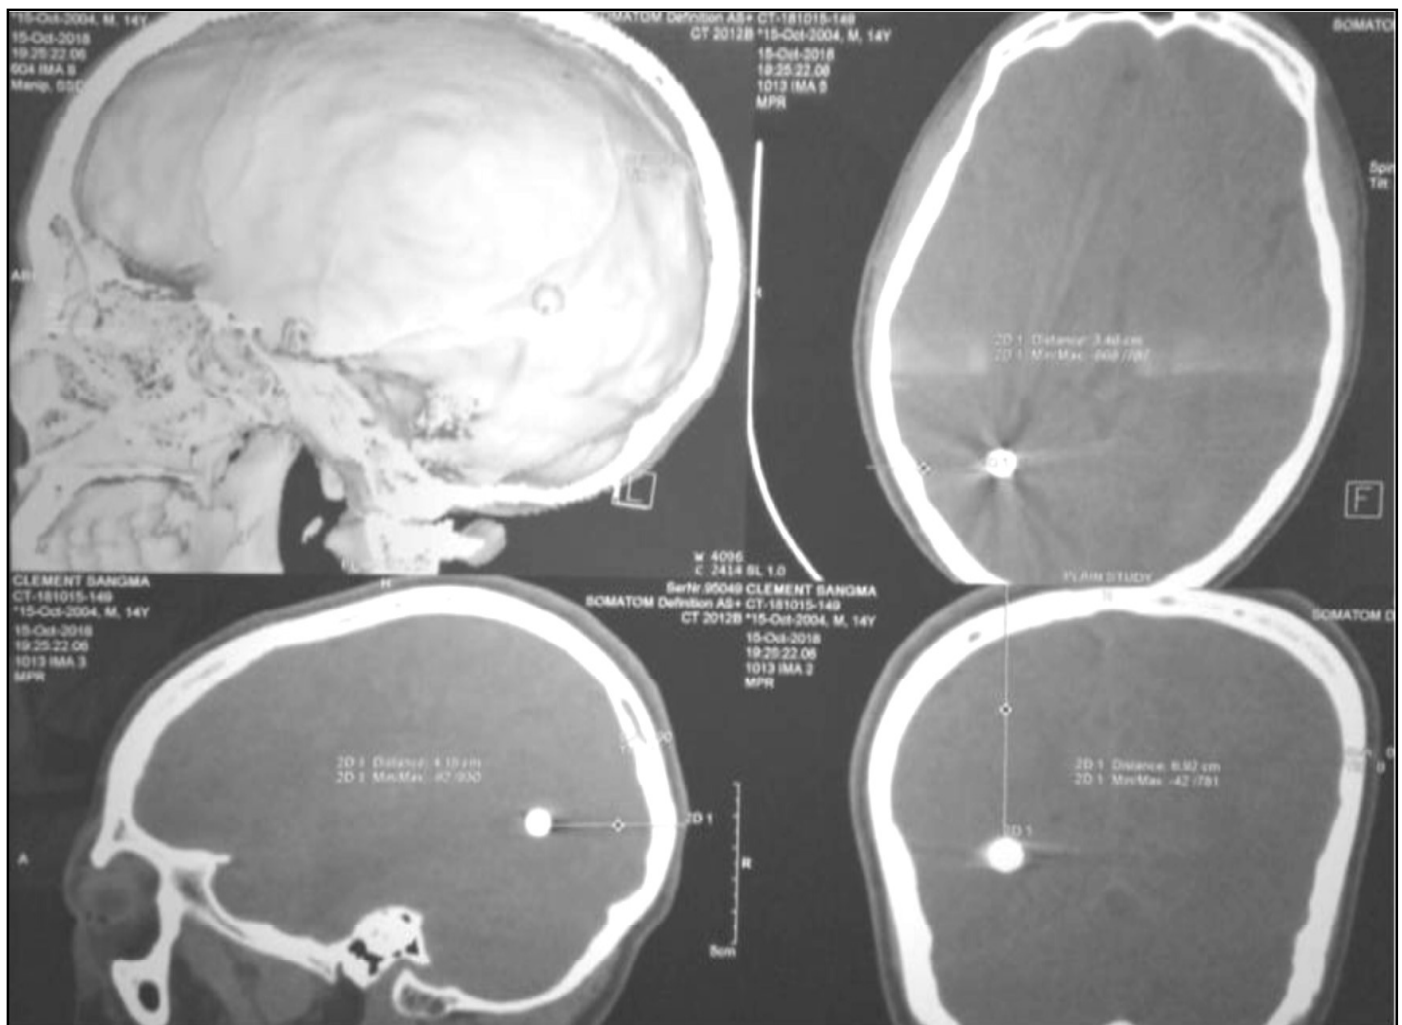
CT scan showing the bullet position and bullet track
